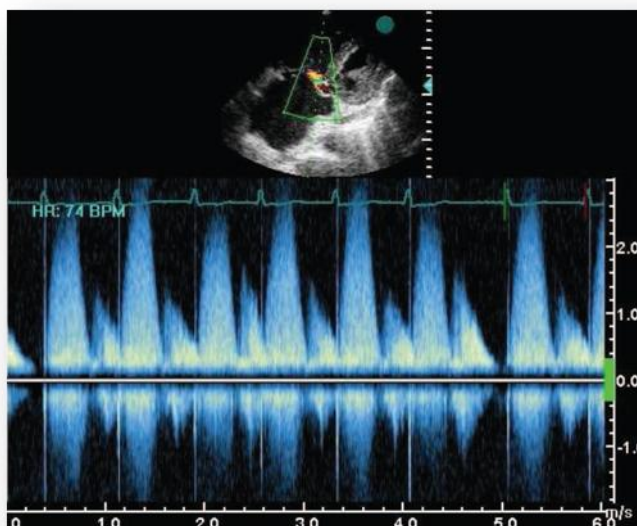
Intracardiac connection found by means of echocardiography examination with Doppler flow evaluation (maximum systolic velocity – 3.5 m/s): fistula between the left ventricle and right atrium
